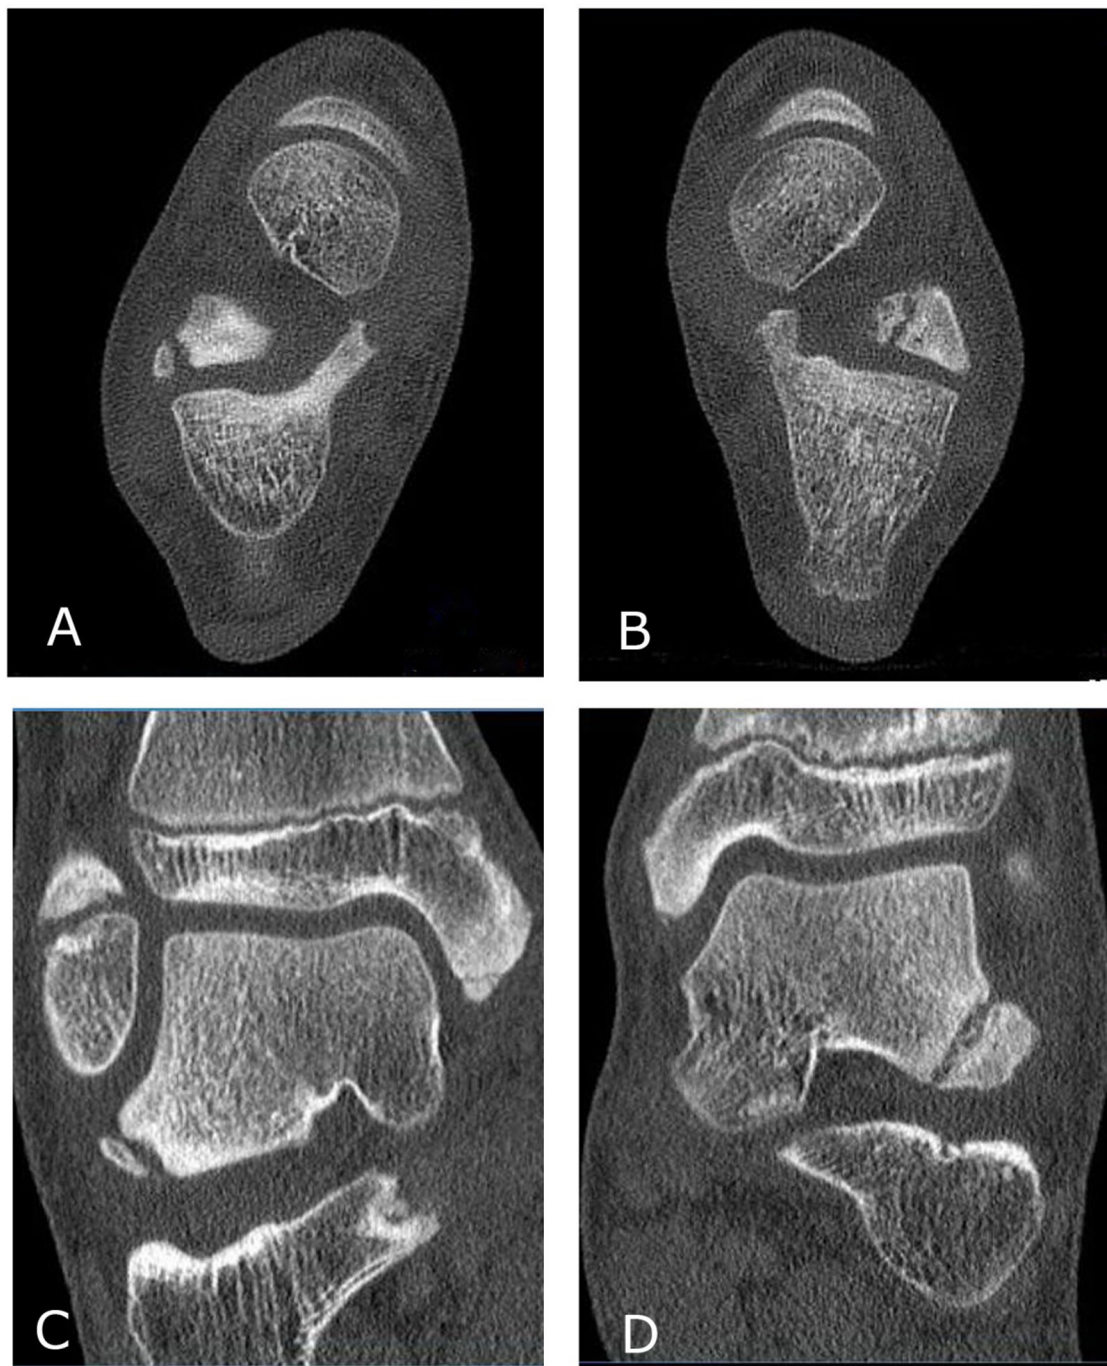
Computed tomography of both ankles showed a bilateral talus secundarius. A and C: right ankle small rounded ossicle ($7 \times 5 \times 2$ mm). B and D: large fragment ($17 \times 15 \times 10$ mm) with small cysts at the level of synchondrosis.
